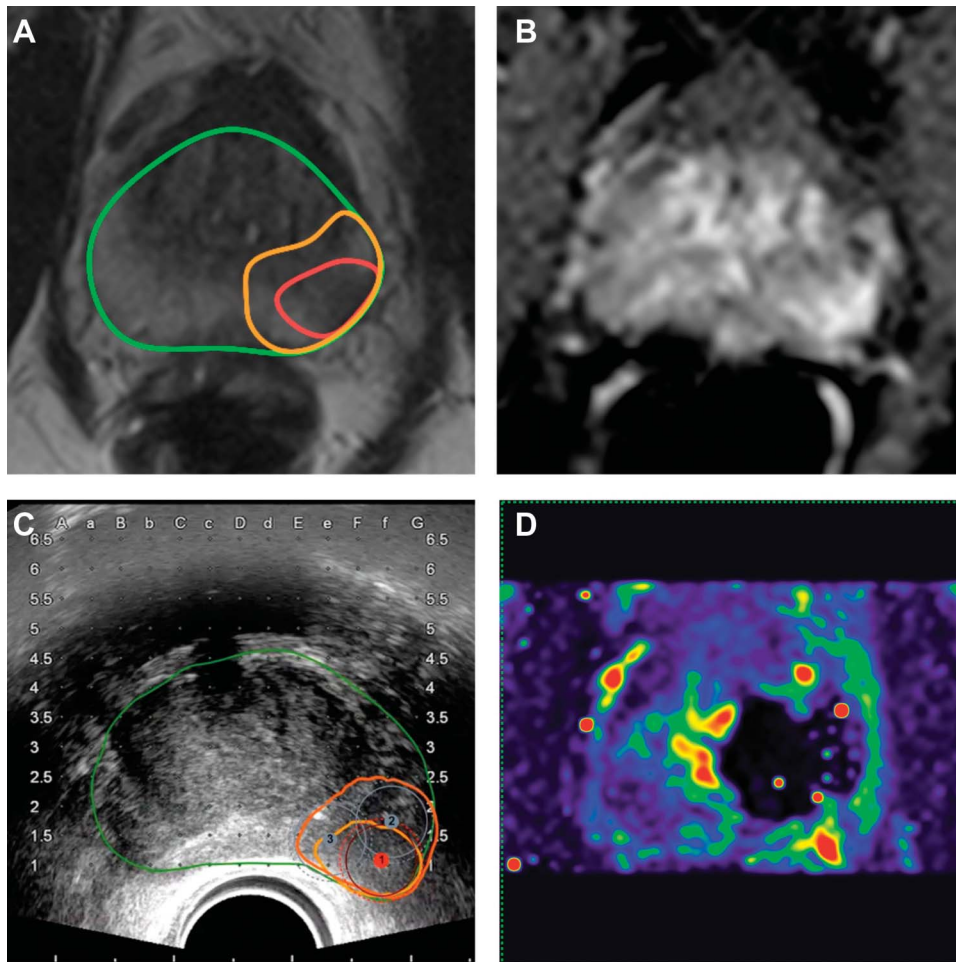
68-Year-old enrolled patient presenting with localized prostate cancer Gleason 7 (3+4) with maximum core length of 11 mm of left peripheral zone. *A*, T2-weighted imaging with segmented prostate (green line) and lesion (red line) augmented by preplanned margin (orange line). *B*, DCE weighted imaging at matching level of *A*. *C*, intraoperative ultrasound with fused MRI derived lesion with compensation of deformation induced by endorectal probe. Circles 1, 2 and 3 represent treatment planning and coils to be inserted to perform complete ablation of cancer with margin. *D*, mpMRI DCE weighted imaging at 5 days post-treatment shows necrosis in location of targeted cancer and living tissue around it.
